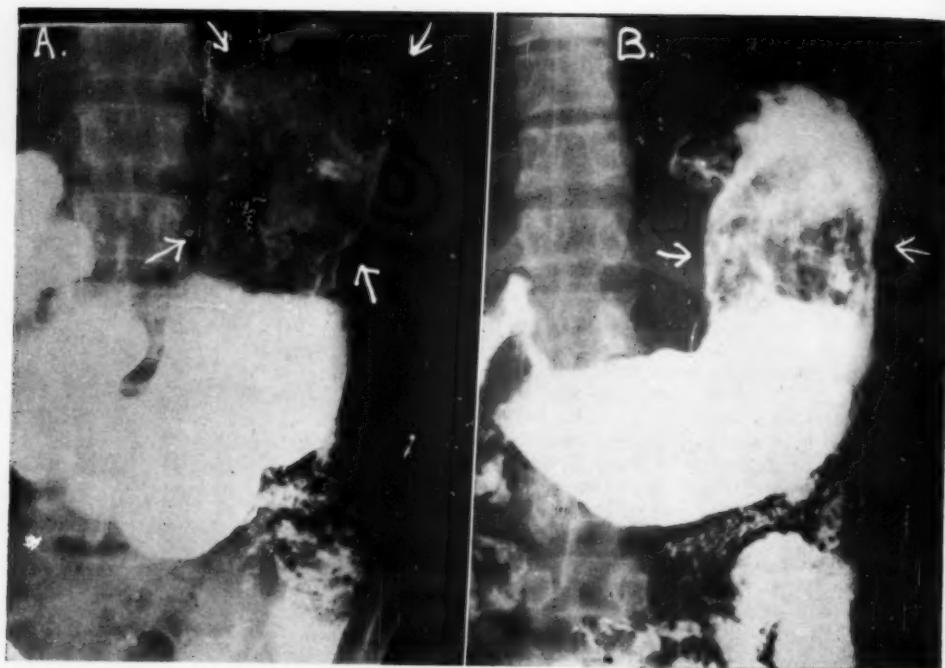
Case 4: Large bezoar in upper part of stomach. A. Roentgenogram taken in upright position. B. Roentgenogram taken in prone position. Arrows indicate position of bezoar.
